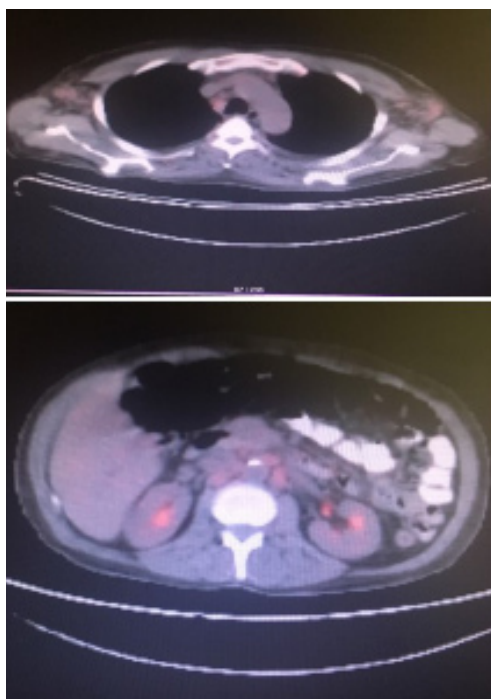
PET CT shows hypermetabolic axillary, mediastinal, intraabdominal and inguinal lymph nodes (SUVmax 3.85-4.70) (Case 3).
